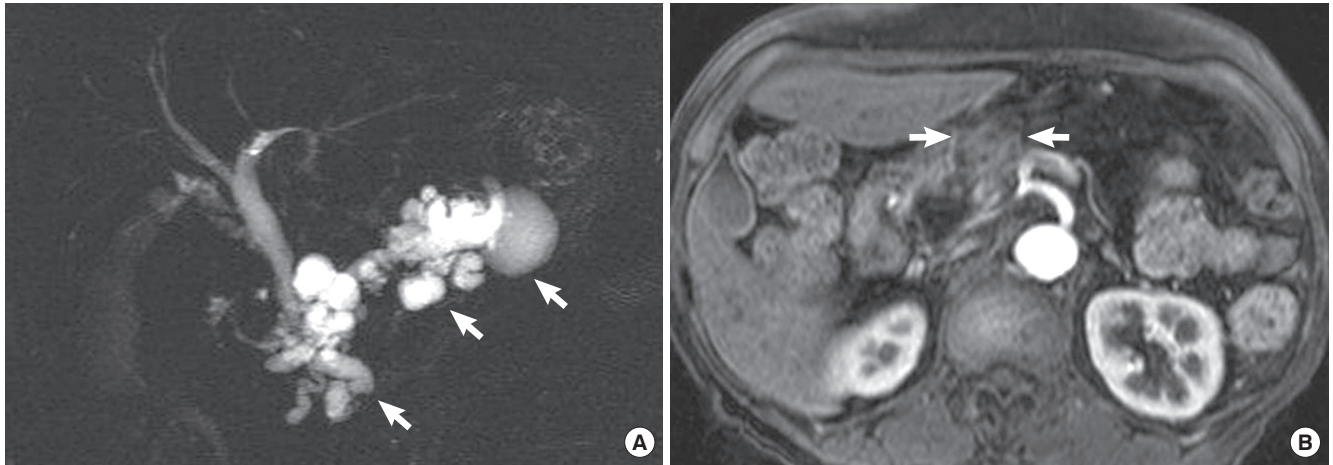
Images of the pancreatic lesions. (A) The coronal single-projection thick-section rapid acquisition with relaxation enhancement MR cholangiography showed a tortuously dilated main pancreatic duct with adjacent variable sized multiple cysts (arrows). (B) An axial, pancreatic phase, three-dimensional MRI after the administration of gadopentetate dimeglumine showed an area of ill-defined, focally decreased signal intensity in the pancreatic neck portion (arrows).
